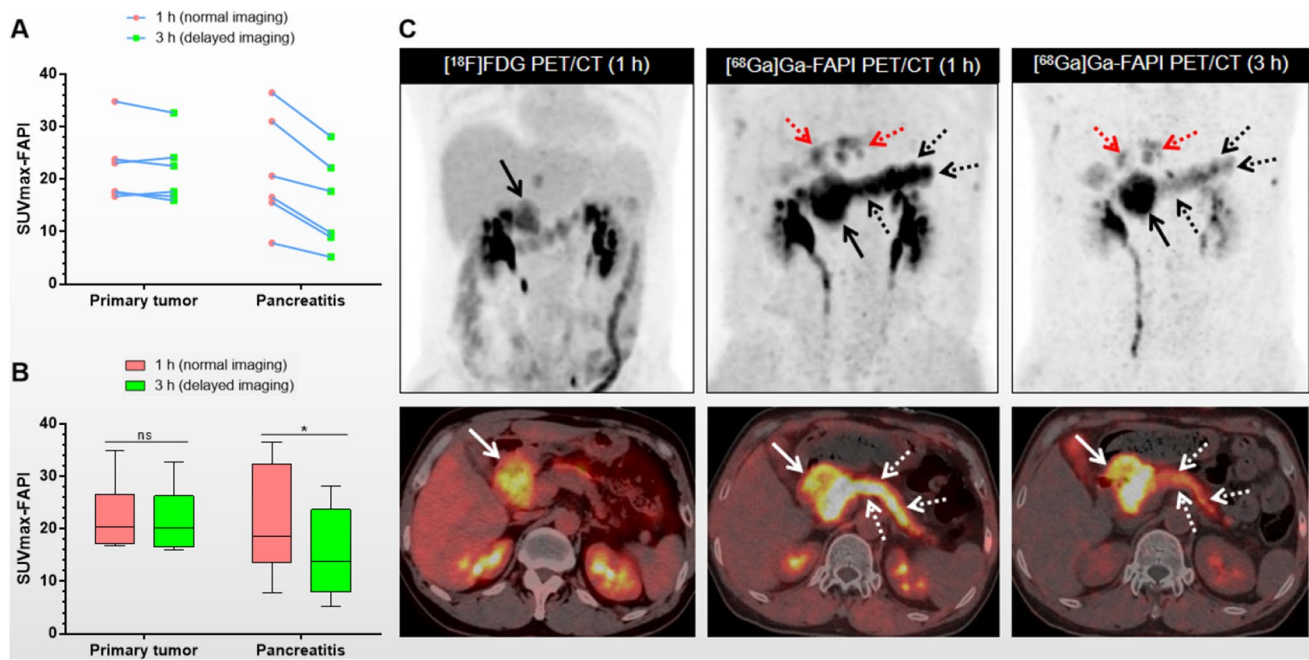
[⁶⁸Ga]Ga-labeled fibroblast activation protein inhibitor ([⁶⁸Ga]Ga-FAPI) uptake assessment of six patients with pancreatic cancer and pancreatitis in a 1-h normal image and a 3-h delayed image. The trend of maximum standard uptake values (SUVmax) of tumor and pancreatitis lesions visualized with FAPI in a 1-h normal image and a 3-h delayed image are shown in A. B The median and range of SUVmax-FAPI for the tumor and pancreatitis in a 1-h normal image and a 3-h delayed image. The representative patient was a 48-year-old man with pancreatic cancer visible on the [¹⁸F]fluorodeoxyglucose ([¹⁸F]FDG) positron emission and computed tomography (PET/CT) scan (C, left line), and the metabolic activity of the primary tumor
